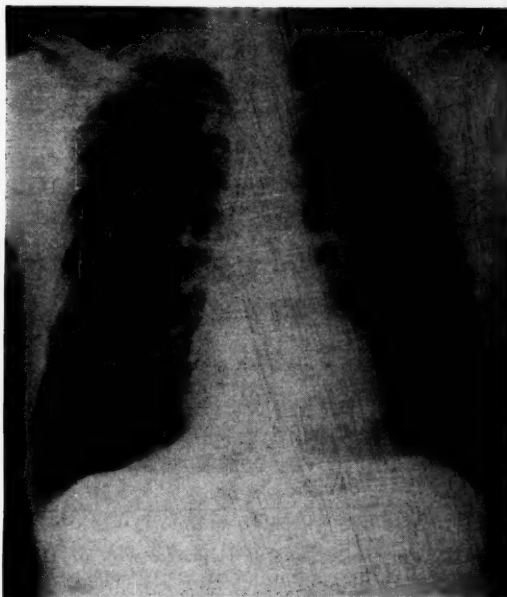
Roentgenogram Revealing Round Homogeneous Density in Left Lower Lung Field. (Case II)
